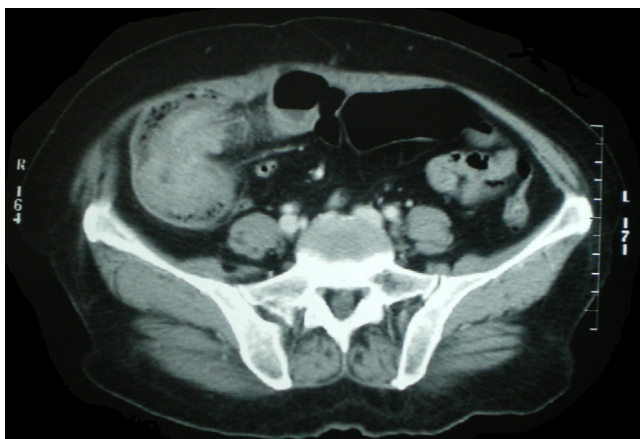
Computed tomography: jejuno-jejunal intussusception.
